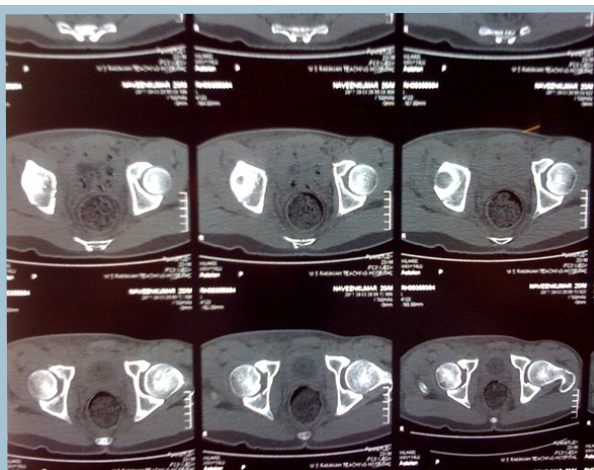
Undisplaced posterior coloumn fracture seen on CT scan
